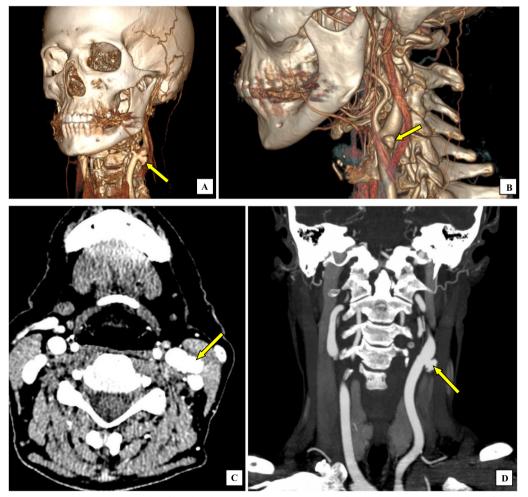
Computed tomography (CT) angiography of head and neck: A, B 3D reconstruction of neck vessels; C, D transversal and frontal views (yellow arrows—pseudoaneurysm of left internal carotid artery, size 11.0×6.0 mm; neck, size 6.0 mm)
